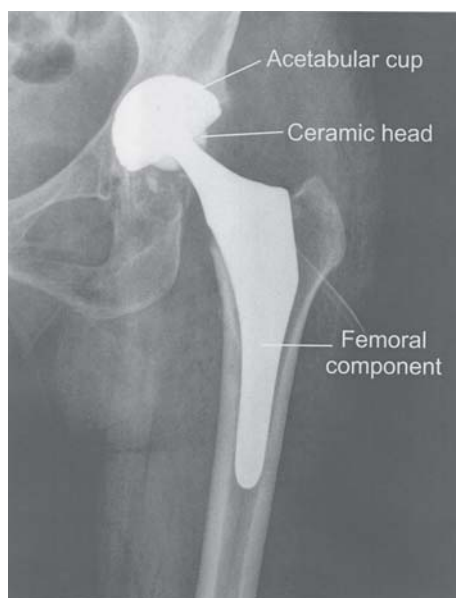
Ceramic-ceramic prosthesis – postoperative antero-posterior X-ray view
